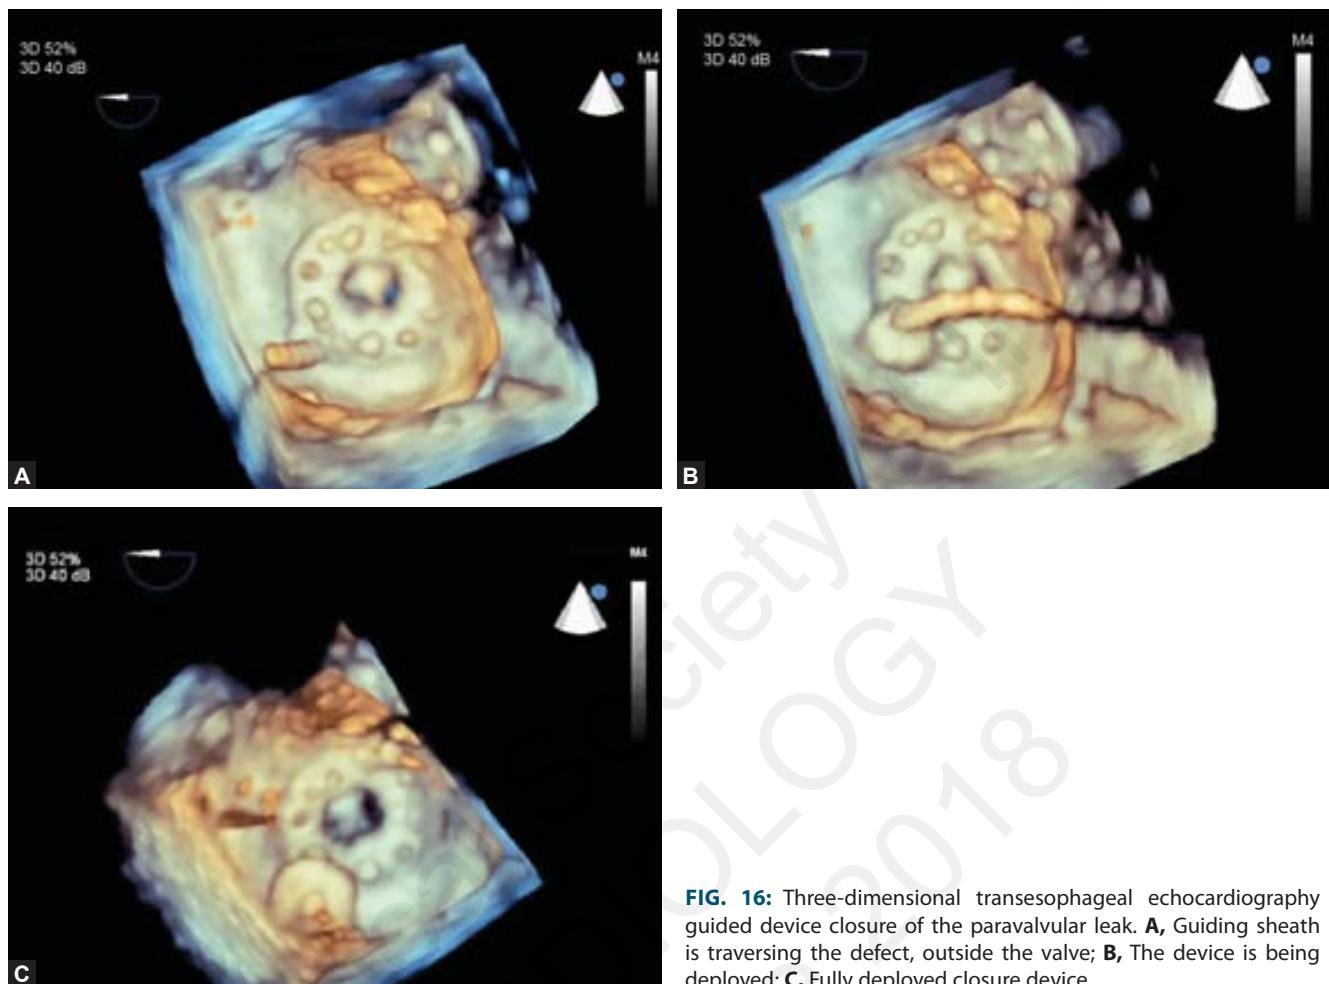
Three-dimensional transesophageal echocardiography guided device closure of the paravalvular leak. A, Guiding sheath is traversing the defect, outside the valve; B, The device is being deployed; C, Fully deployed closure device.
